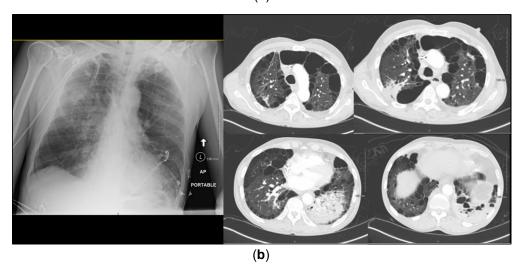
A representative chest radiograph of a 64-year-old female hospitalized with community-acquired pneumonia with a test positive for endemic human coronavirus (no co-infection) (a) and a similar patient, but who had chronic obstructive pulmonary disease (b).
